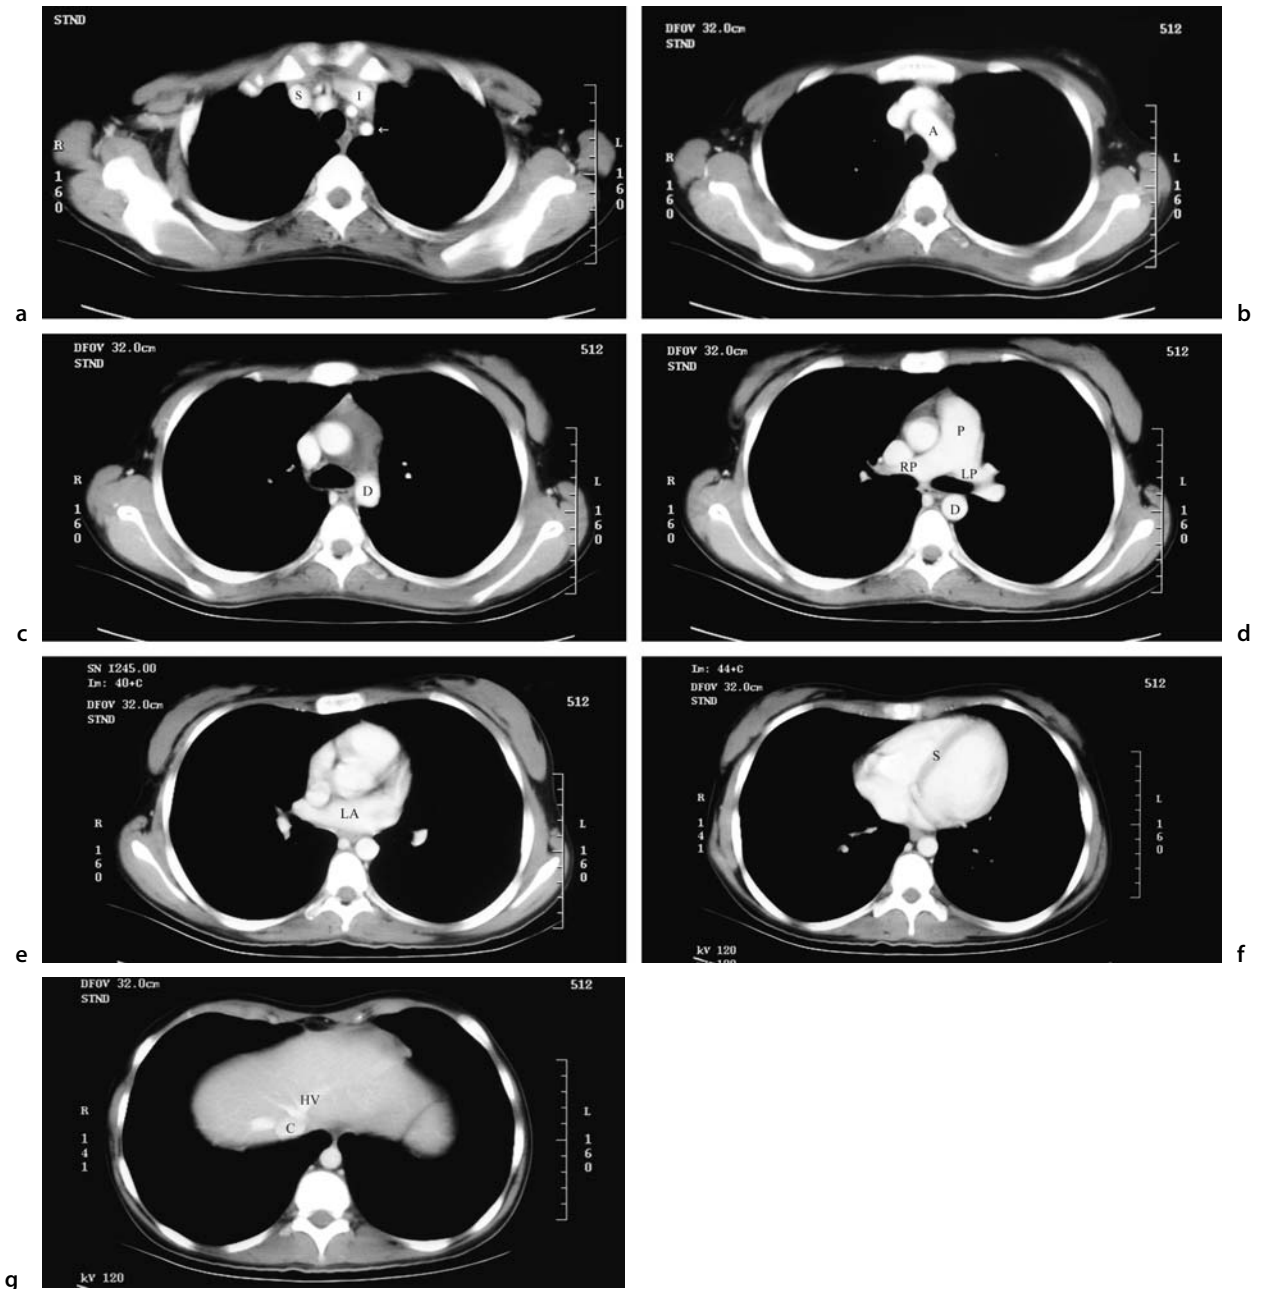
Normal contrast-enhanced CT of the mediastinum (axial projection). Remember the vessels in the heart “light up”
